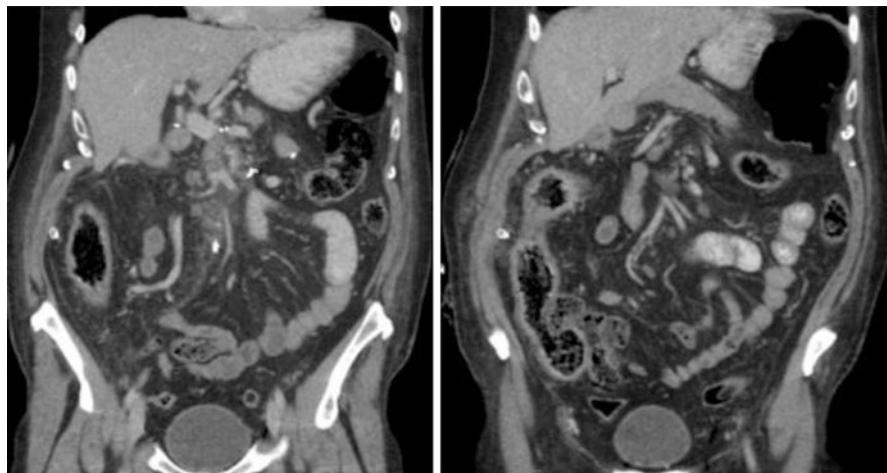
Complicated portal vein thrombus. Portal venous-phase CT abdomen demonstrating portal vein thrombus (left) with resultant thickening and paracolic fat stranding of the ascending colon indicating ischaemia (right) in a patient 8-days following Whipples procedure with portal vein lateral venorrhaphy. This presented 8-days following surgery and was associated with thrombocytopenia. A diagnosis of heparin-induced thrombocytopenia was diagnosed. The patient was anticoagulated with fondaparinux and his condition improved without further intervention
